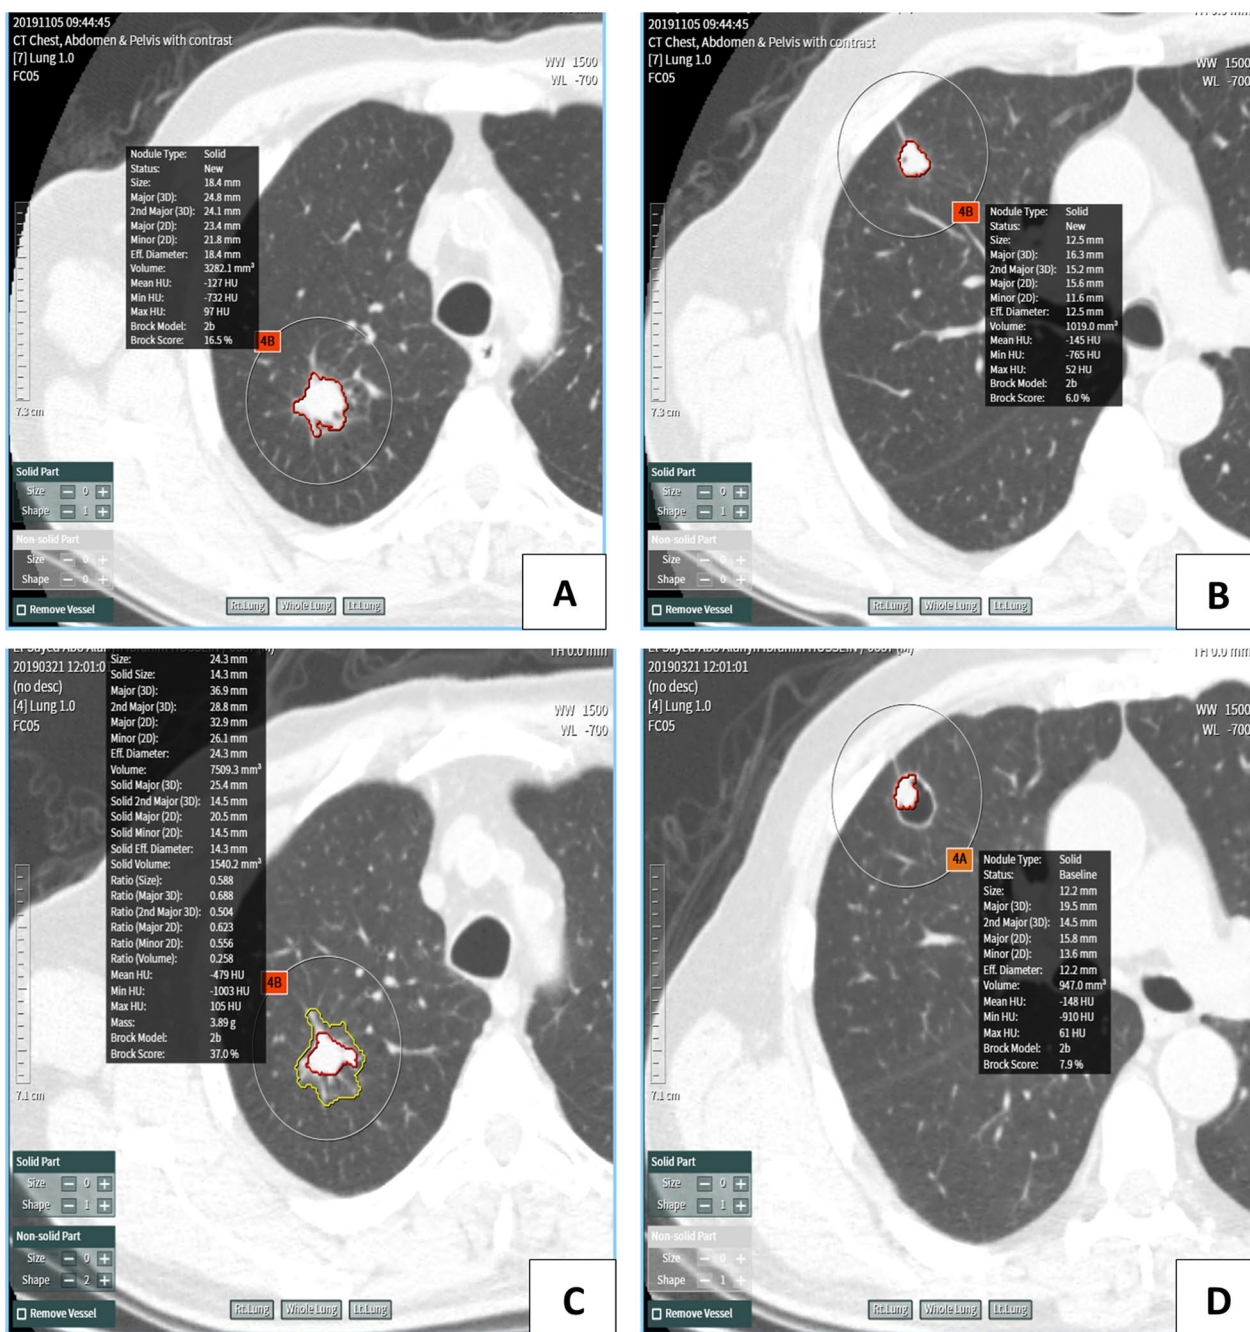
A, B: base line axial CT of two pulmonary nodules, C, D: follow-up scan showed change in morphology
